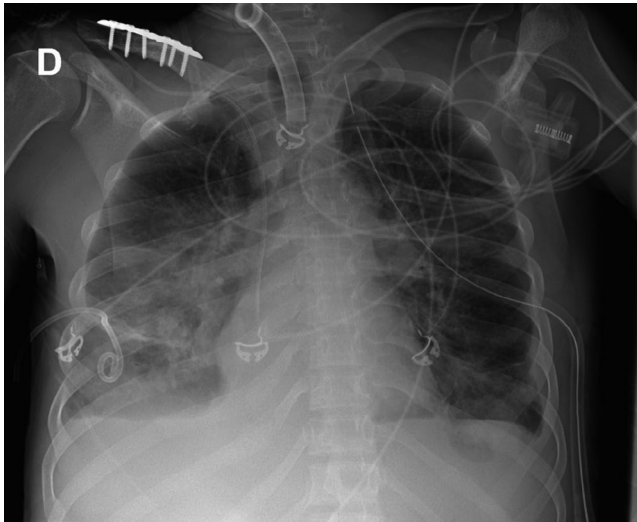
Chest X-ray the day before the placement of the vv-ECMO machine for patient 2. It shows the tracheostomy, right inferior pneumonia, and bilateral chest drains. The X-rays show opacities that may be caused by pneumonia or contusion
